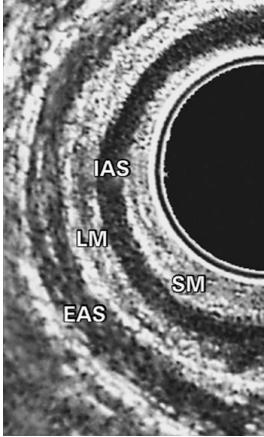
Layers of the anal canal by ultrasound; IAS = internal anal sphincter; LM = longitudinal muscle; SM = submucosal; EAS = external anal sphincter
